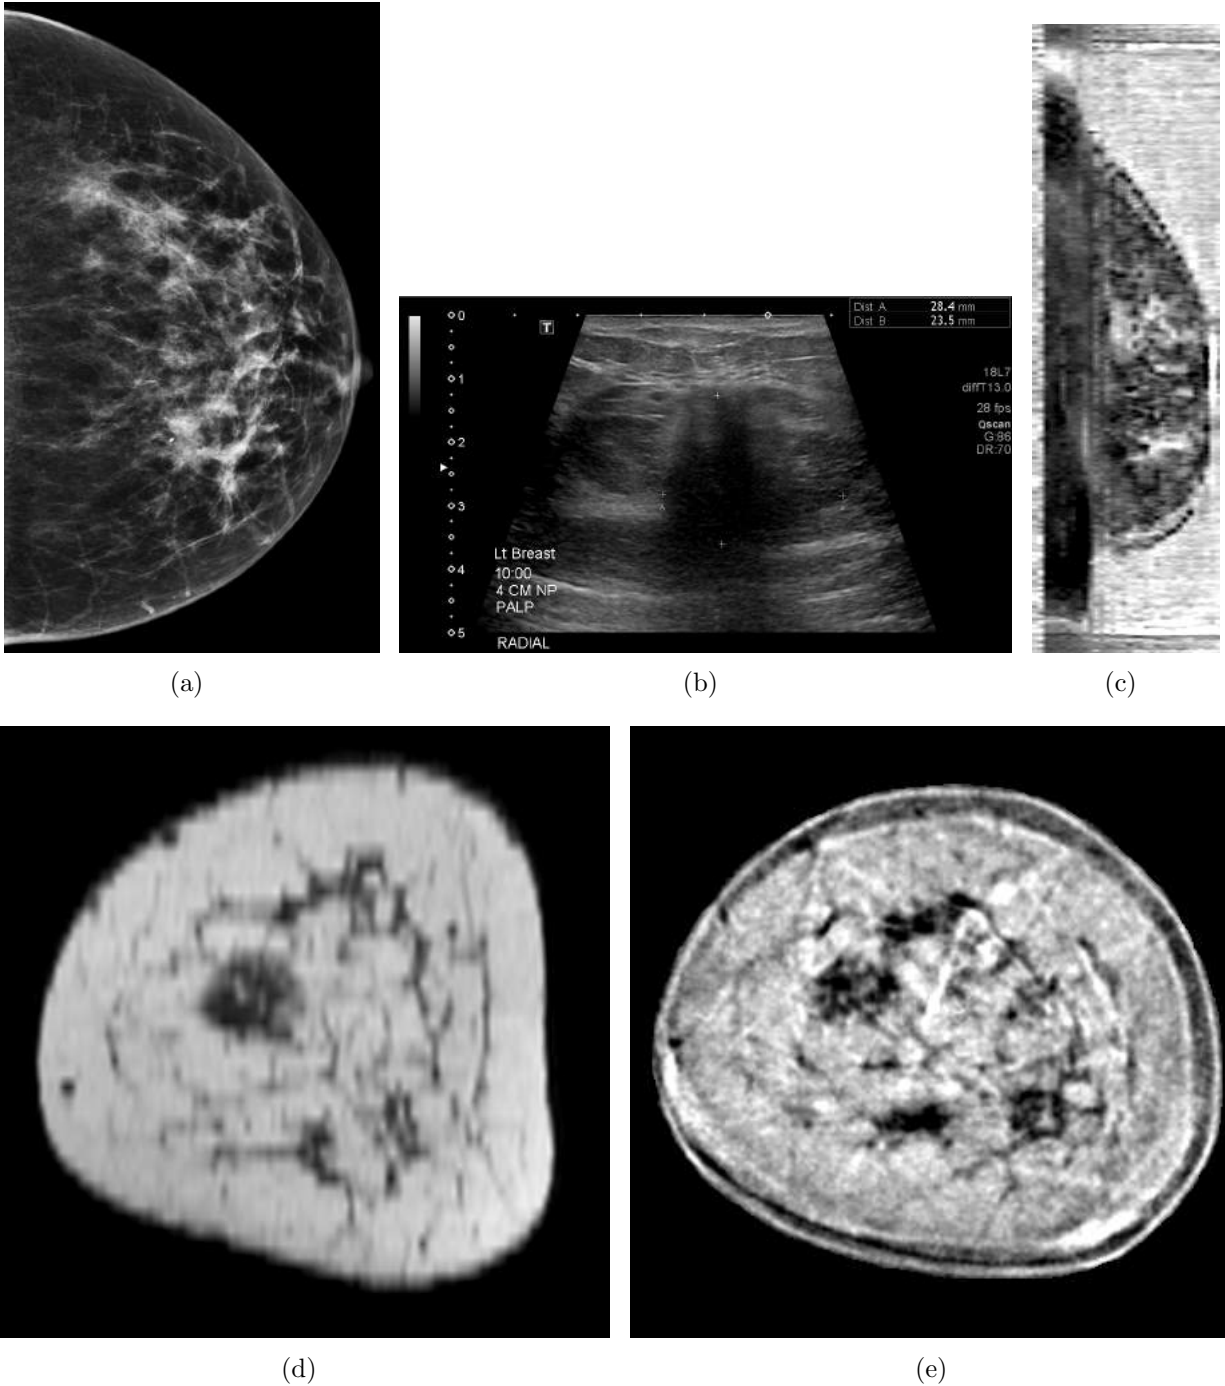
Images Corresponding to Case 1. (a) Cranial-Caudal mammogram. (b) Hand-Held ultrasound. (c) Waveform sound speed re-sampled in sagittal plane. (d) MRI. (e) Waveform sound speed with inverted gray scale.
